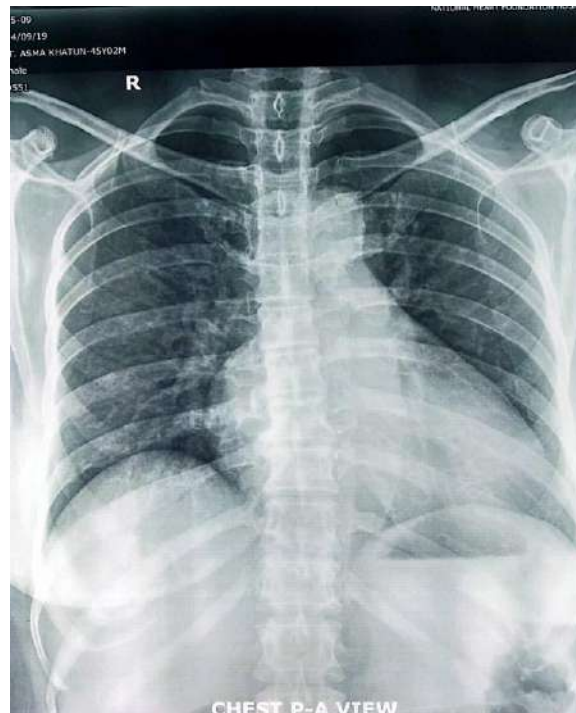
Chest radiograph showed dilated RA with normal congestion of the pulmonary vasculature.
